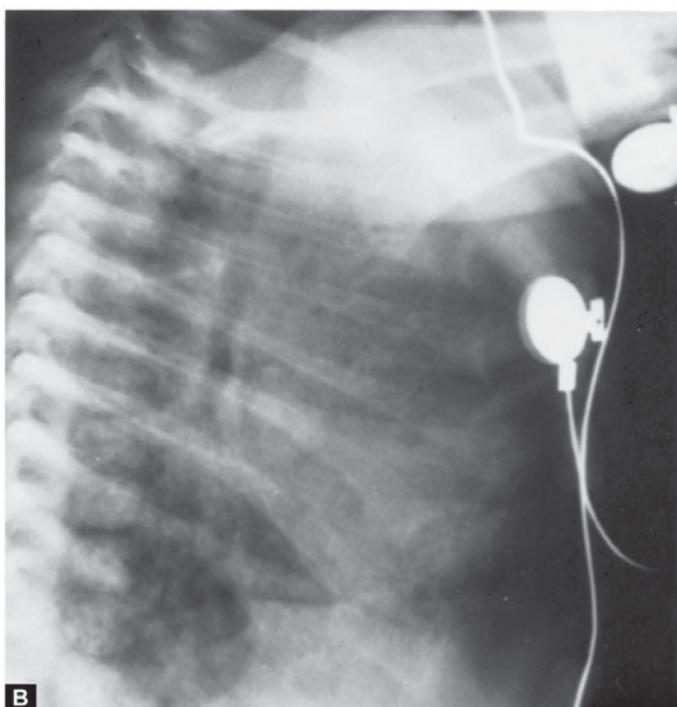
A. Anteroposterior and B., lateral chest radiographs of a severely ill 1-month-old male infant with chlamydial pneumonitis. Diffuse interstitial infiltrates and hyperaeration with flattened diaphragms are prominent.
